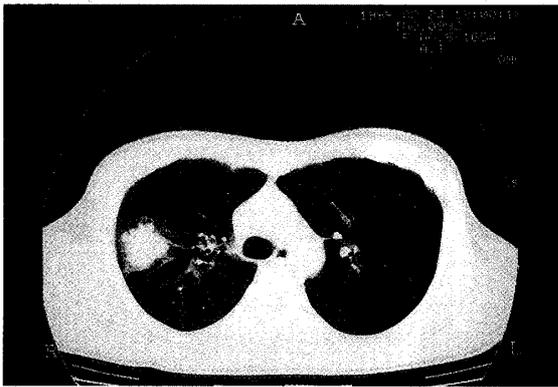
A. Computed tomograph of the chest revealing a mass in the right upper lung. : pulmonary window
